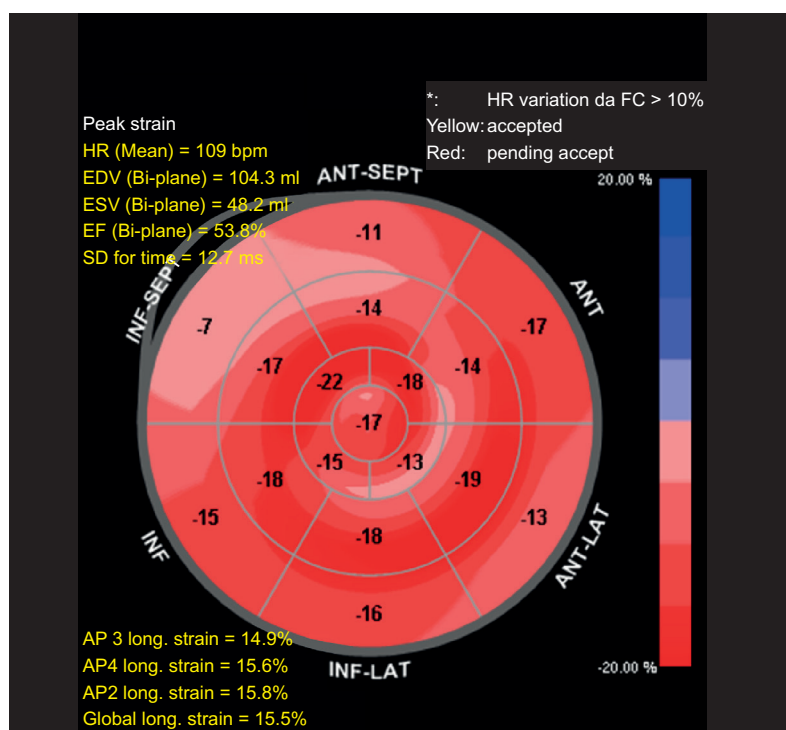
Global longitudinal strain of the first echocardiogram with discrete reduction.
